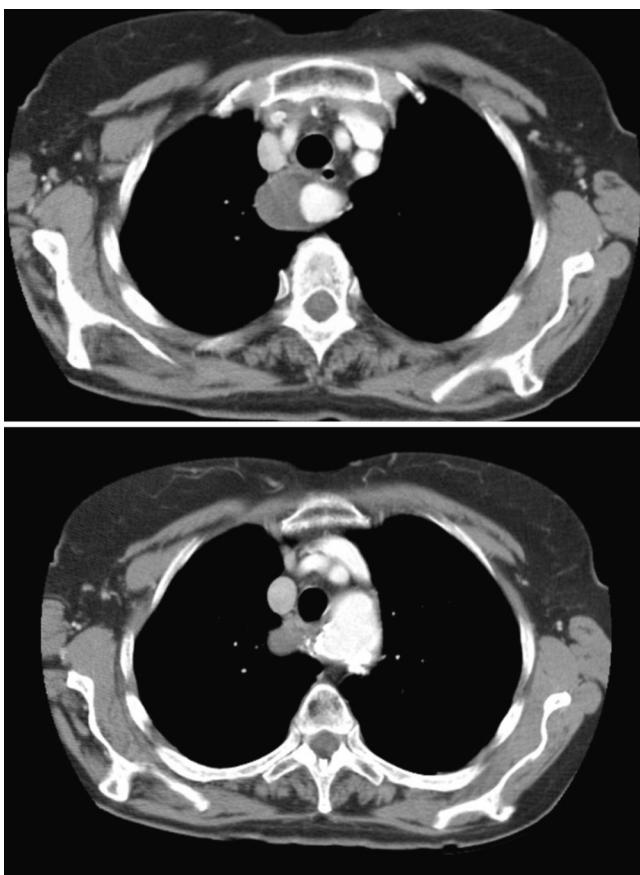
Pre-operative angio-CT scan showing the aneurysmal ARSA 32 mm in diameter with Kommerel's diverticulum.
